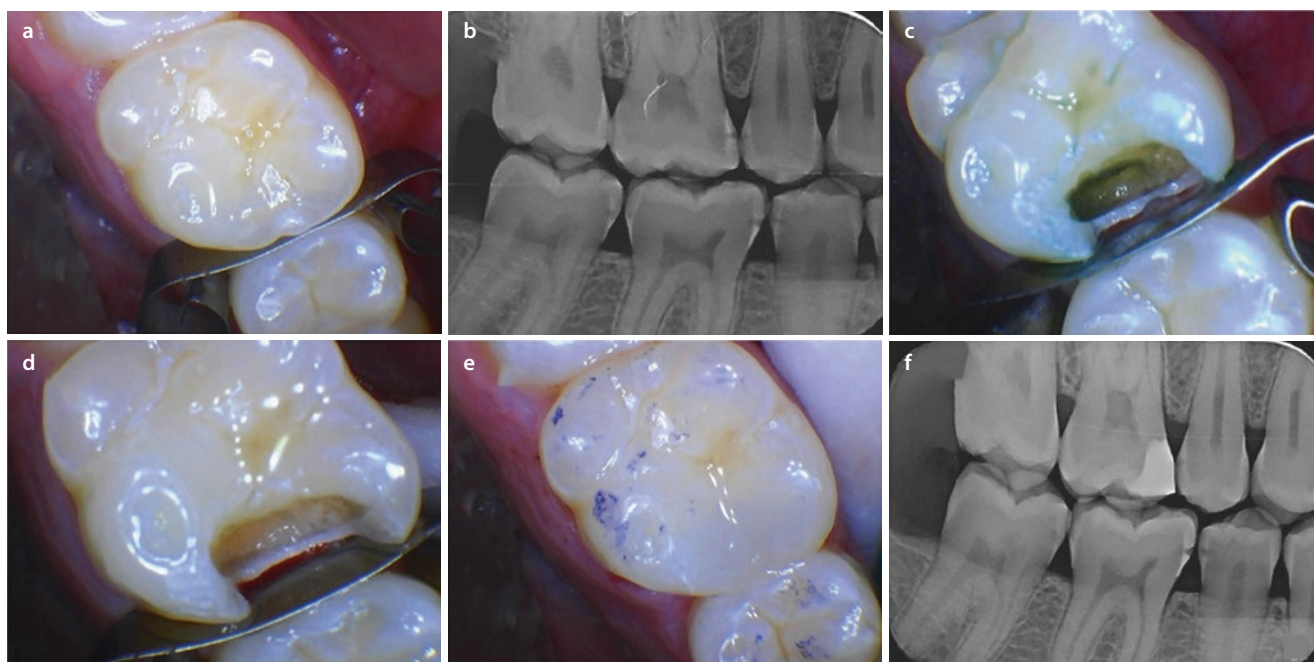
Carious tissue removal in tooth #3 MO using Solea CO₂ 9.3 μm laser (Convergent Dental, Natick, MA, USA). Image key: a preoperative occlusal view of the upper right molar with a carious lesion on the mesial surface. b Preoperative radiograph. c A photo of the partially completed carious lesion excavation. The 9300 nm laser with a 1.25 mm spot size was used with a cutting speed between 20% and 60%. Caries indicating solution was used to verify the progress of the preparation. Subsequently the laser was used with a 1.0 mm spot
